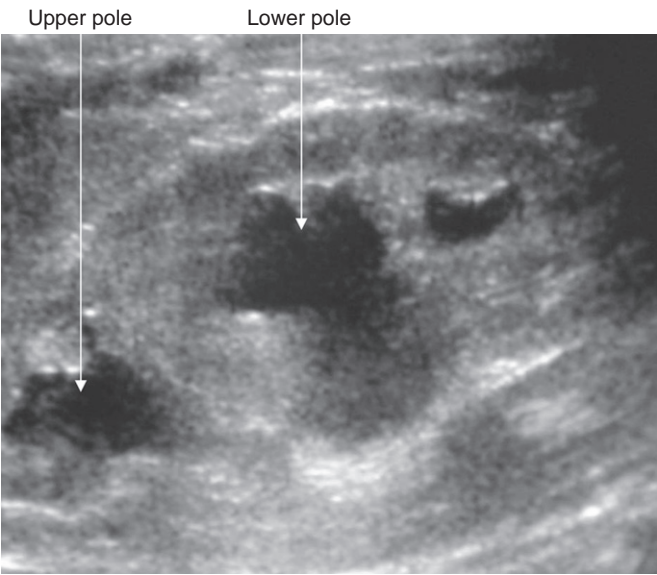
Sagittal ultrasonography of a kidney demonstrating a duplicated collecting system.
